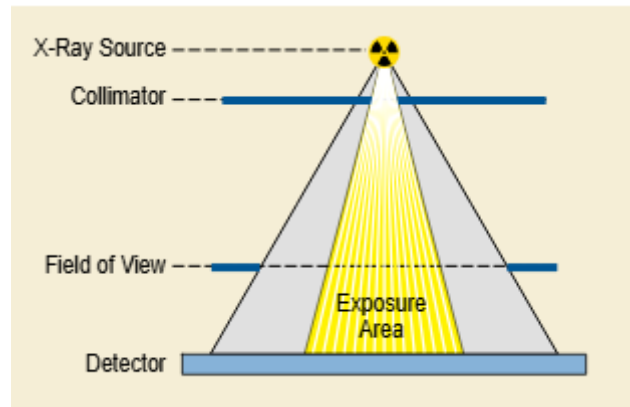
4 Geometric relationships in CT scanning [42].
